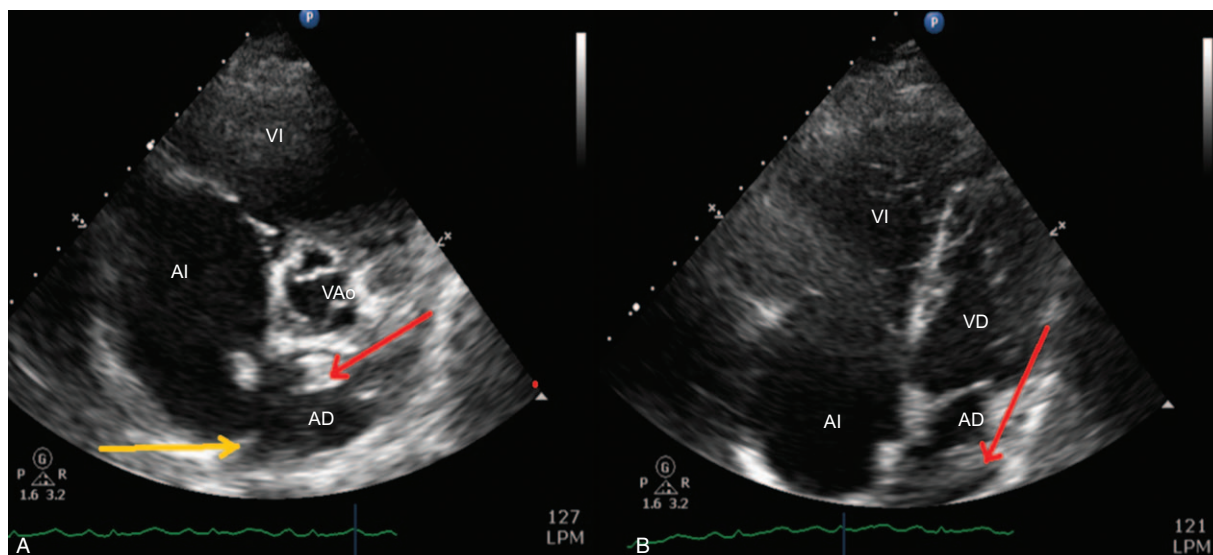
Transthoracic ultrasound. (A) Parasternal view. (B) Four chamber view. Right atrium (AD), left atrium (AI), right ventricle (VD), left ventricle (VI), aortic valve (VAo), patent foramen ovale (yellow arrow), thrombus (red arrow). Source: Authors.
